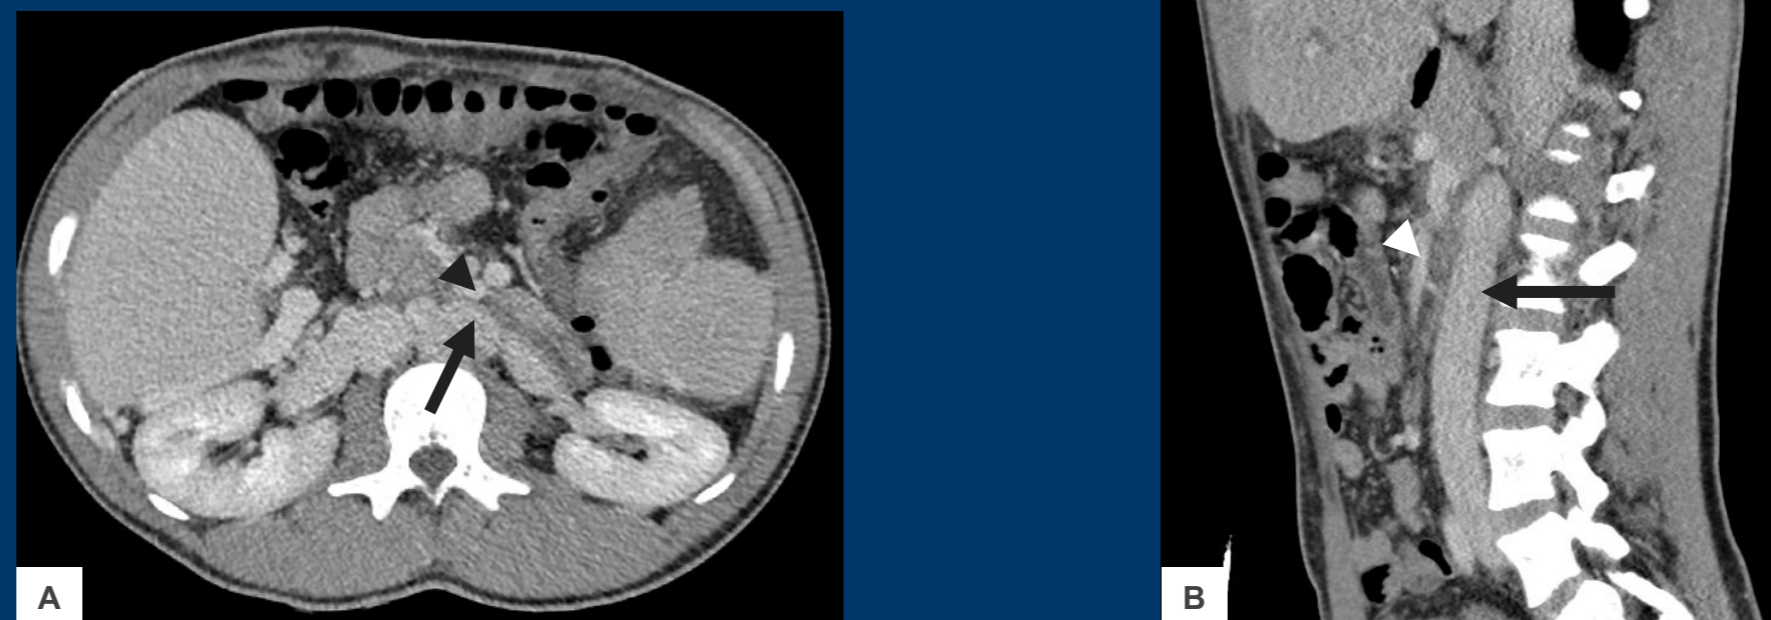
Axial (A) and sagittal CT reformats (B) showing the relation between the IVC (arrow) and SMV (arrowhead). These images were utilized to plan the successful transcaval approach.
